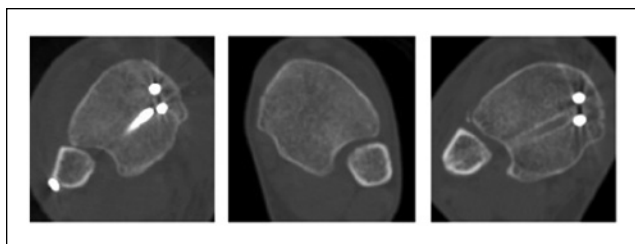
CT scans of a 21-year-old male with a Weber C ankle fracture with associated medial malleolus fracture treated with open reduction internal fixation including two 3.5 mm tricortical syndesmosis screws. Immediate postoperative CT scan (left) shows anterior malreduction of the operative fibula with increased posterior fibular-incisura distance compared to the uninjured ankle (middle). The postsyndesmosis screw removal CT (right) shows improved but continued malreduction with anterior translation of the fibula.
